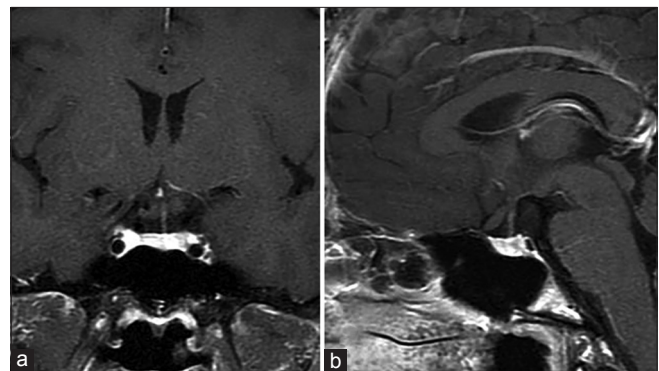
Postoperative (a) sagittal and (b) coronal images of gadolinium-enhanced MRI at 12 months after surgical resection show no residual tumor in the suprasellar region
